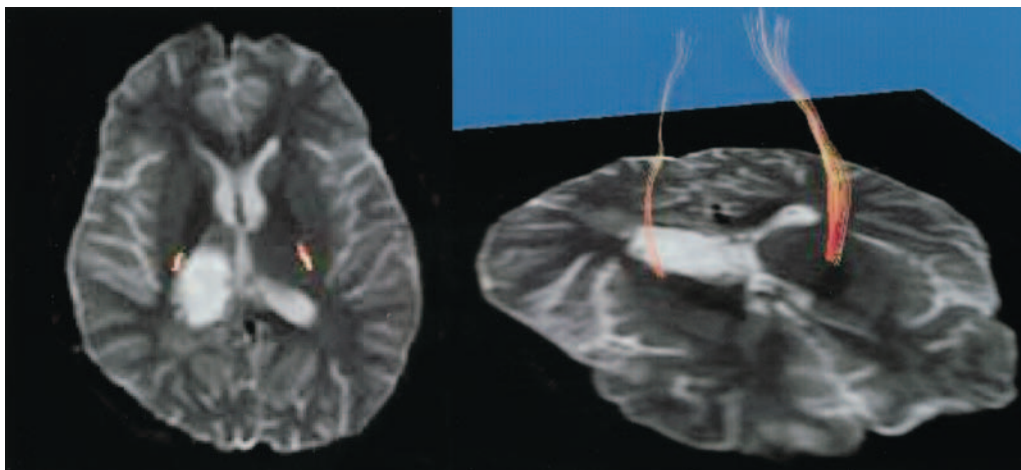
Case 1. Postoperative T₂-weighted MR images with the superimposed CST demonstrating that the preserved CST remains anterior to the tumor cavity.
